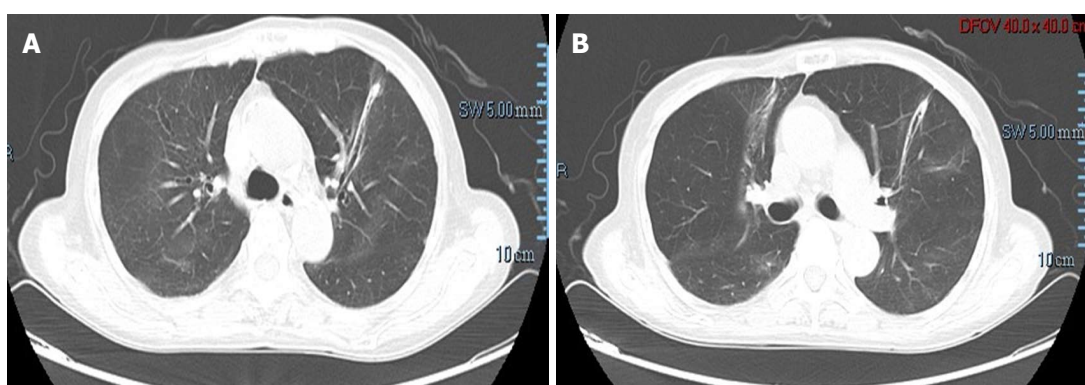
Repeat chest computed tomography scan after 3 wk steroid treatment showed significant improvement, and bilateral lesions almost disappeared.
